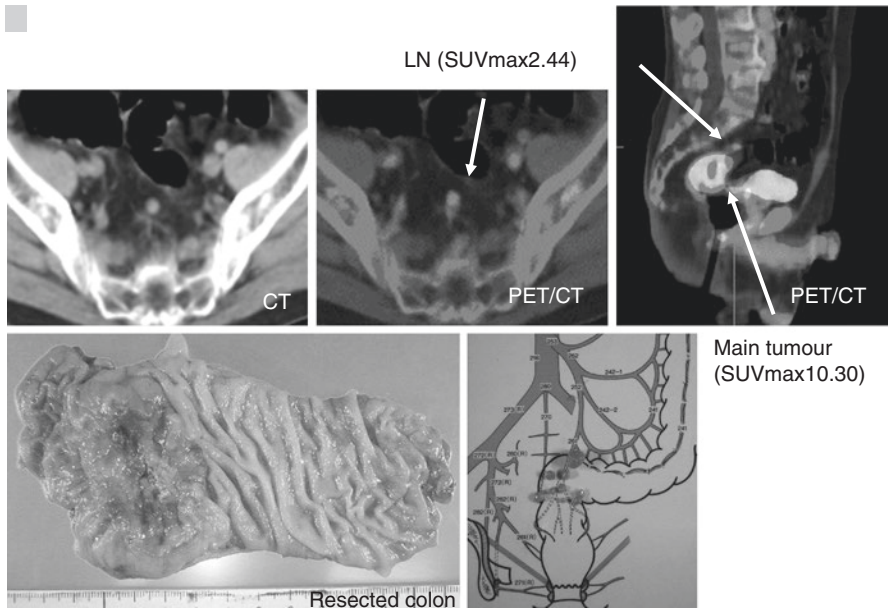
The patient was a 78-year-old man with rectal cancer with proximal lymph node metastasis. Accumulation of FDG-PET was detected in the proximal lymph node
